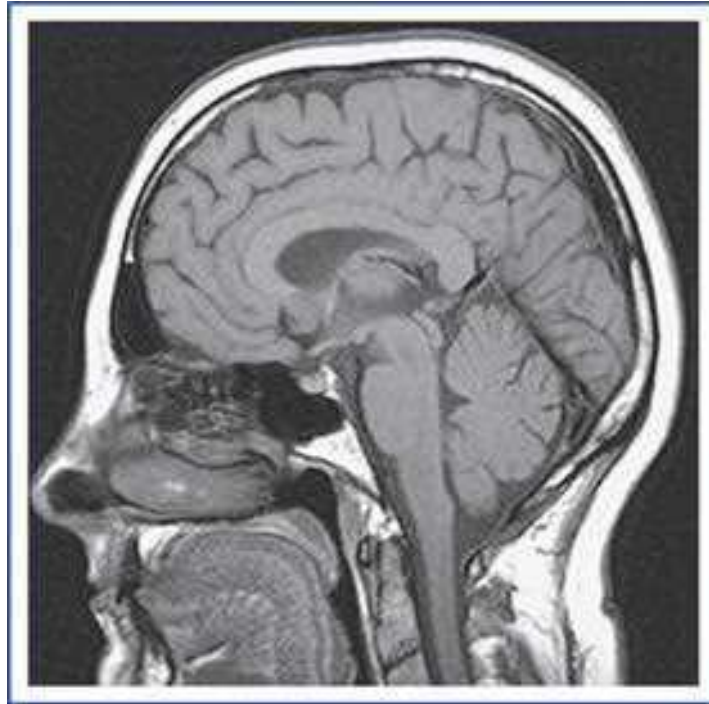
A sagittal view of MRI of the skull, brain and cranial portion of the spinal cord.
